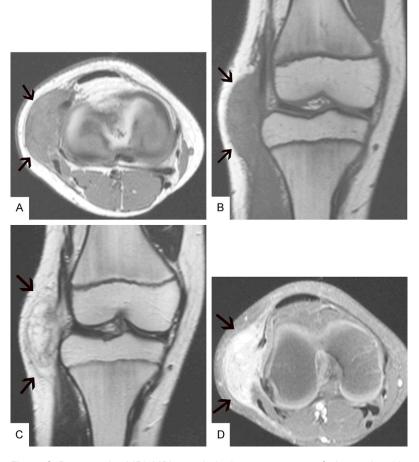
Preoperative MRI. MRI revealed a heterogeneous soft-tissue signal in the right lateral knee. The lesion was isointense signal to normal muscle on the horizontal (A) and coronary view (B) T1-weighted images (*arrows*). MRI showed a hyperintense signal to normal muscle on the coronary view T2-weighted image (C) (*arrows*). The gadolinium enhanced MRI showed a hyperintense signal to normal muscle mixed with some hypointense signal on the horizontal view T1-weighted image (D) (*arrows*).
